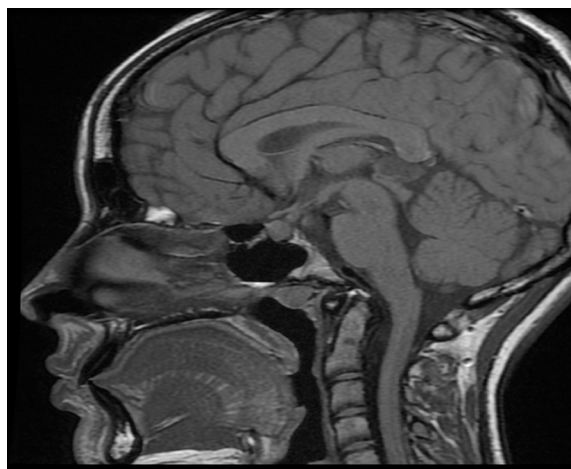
Sagittal T1-weighted image demonstrates a lack of T1-weighted high intensity of the posterior pituitary with associated thickening of the infundibulum.
